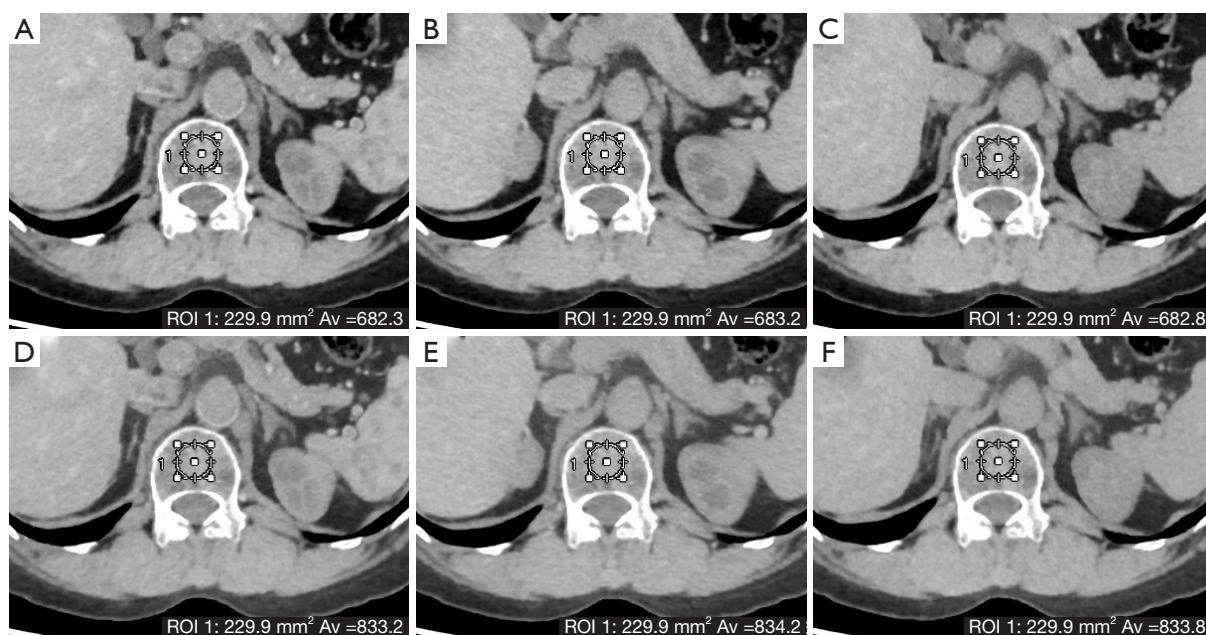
The density values of HAP-iodine (A-C) and Ca-iodine (D-F) were measured in triphasic enhanced CT. (A,D) Arterial phase. (B,E) Portal venous phase. (C,F) Delayed phase. ROI, region of interest; Av, average value; HAP, hydroxyapatite; Ca, calcium; CT, computed tomography.
